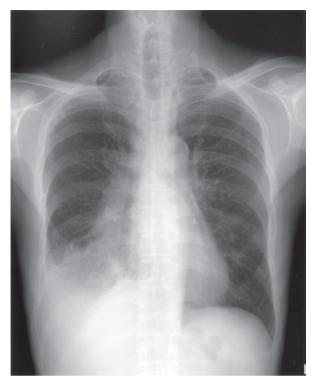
Chest radiograph initially showed an opacifying mass-like lesion in the right lower lung field with a blunted lateral costophrenic angle.
